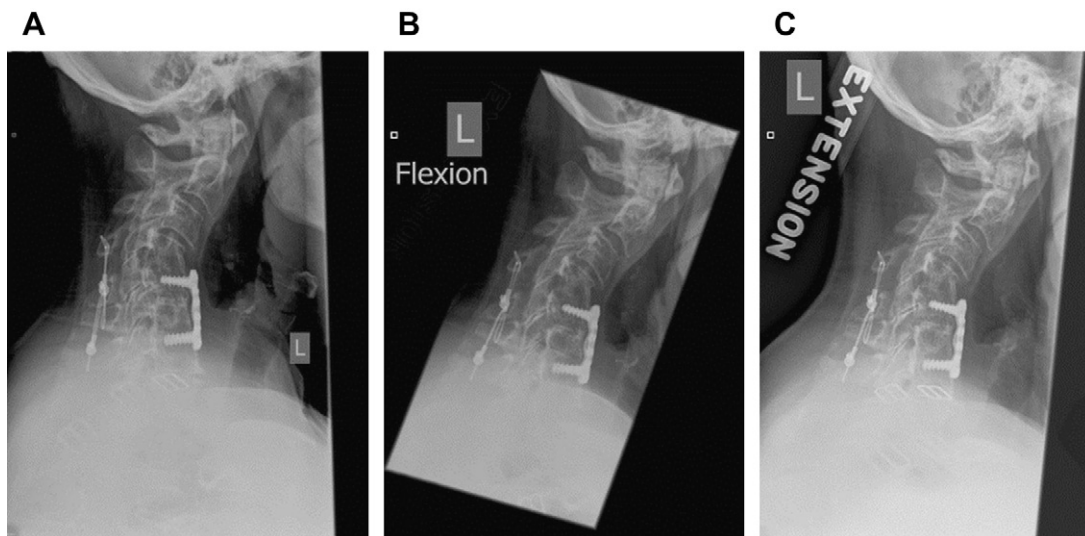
(A) Preoperative lateral radiograph of a patient with fixed cervical kyphosis. Dynamic radiographs assess the extent of rigidity by (B) flexion and (C) extension.
